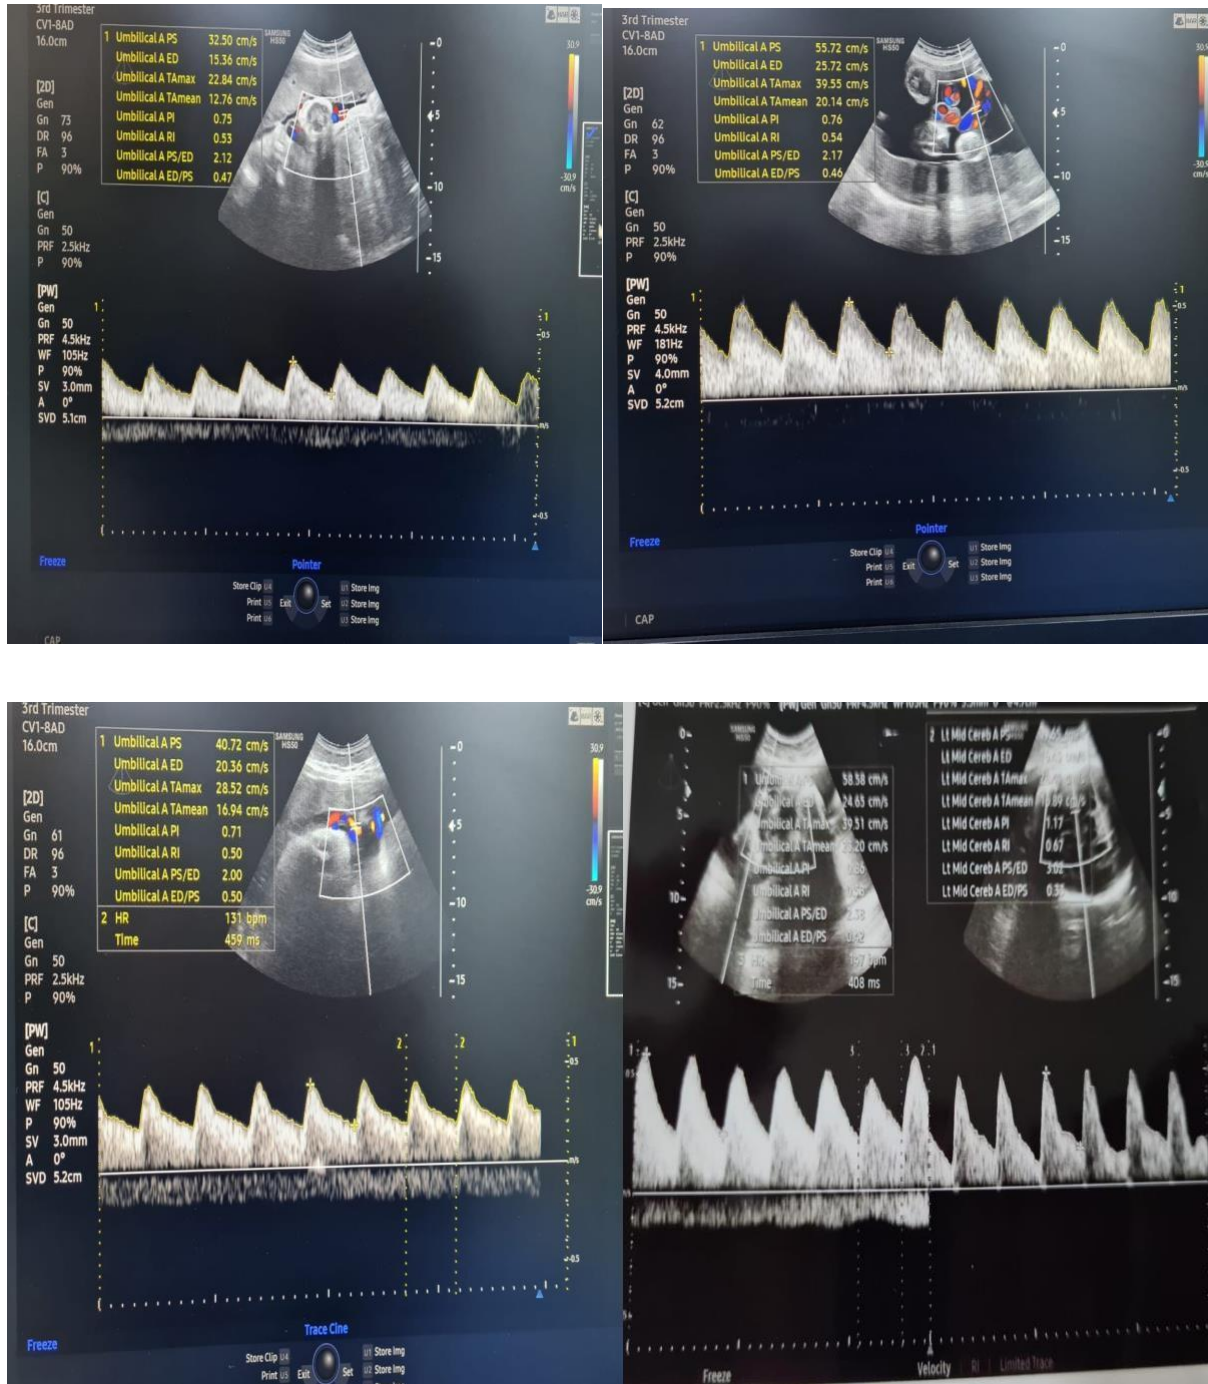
Some doppler ultrasound of studied group
